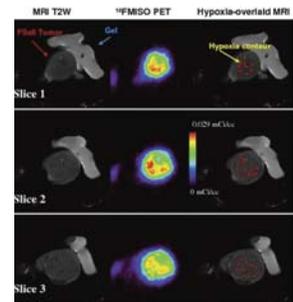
Registration of MRI T2-weighted and <sup>18</sup>F-miso PET images over three transverse slices of a FSaII tumor.
